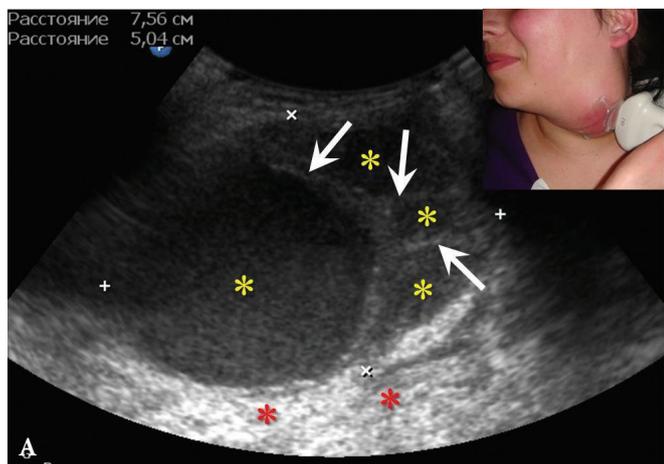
Suppurated multicameral BCC in a 33-years-old female. A sonogram (A) performed by convex transducer shows a cystic lesion (its size are marked with “+” and “x” are equal 7.5- x 5.0- cm) of the left neck with the presence of isoechoic septations (arrows). Anechoic cyst content in cameras are indicated by yellow asterisks, an artifact of acoustic enhancement – by red asterisks. An axial MDCT scan (B) confirms the presence of intracystic septations (arrow). The density of the cystic content is equal to +10, +15 HU. Cameras are marked by asterisks.
